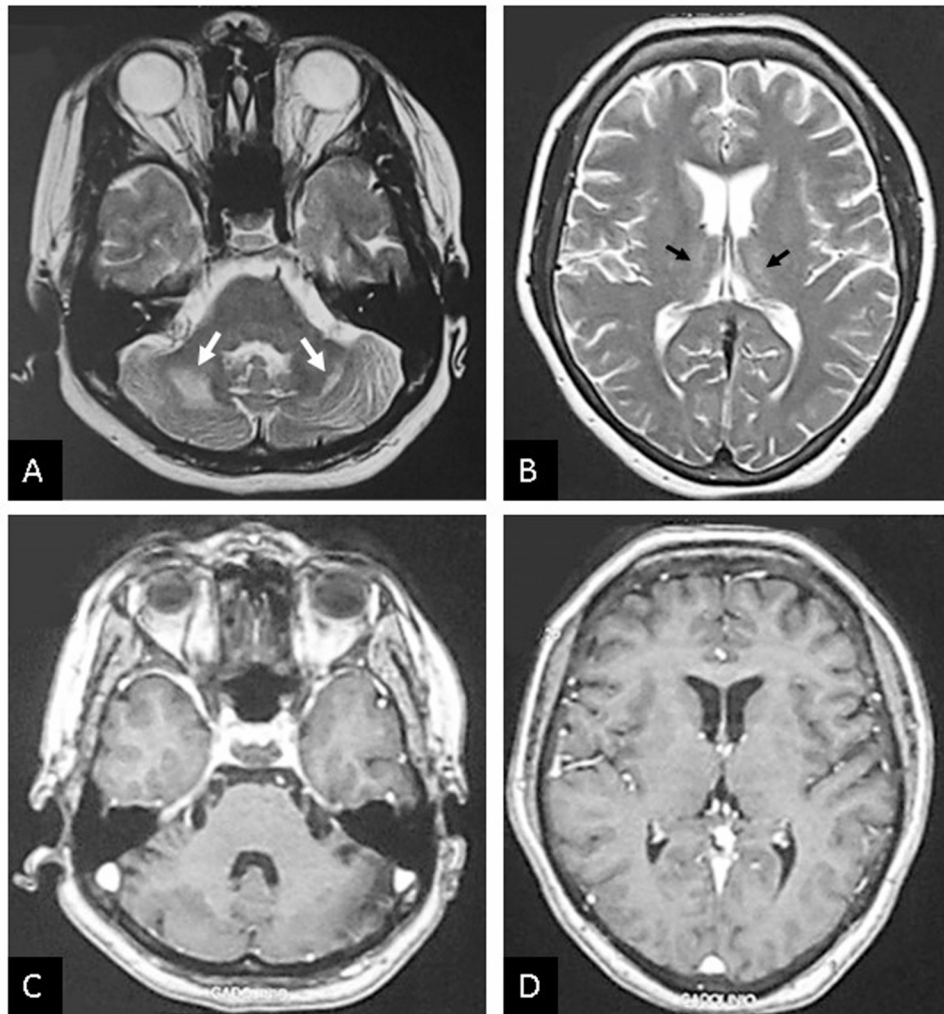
Axial T2-weighted images (A, B) show hyperintense lesions in cerebellar white matter (white arrows) and dorso-medial thalami (black arrows). Post-contrast T1- weighted MRI (C, D) does not show contrast enhancement.
